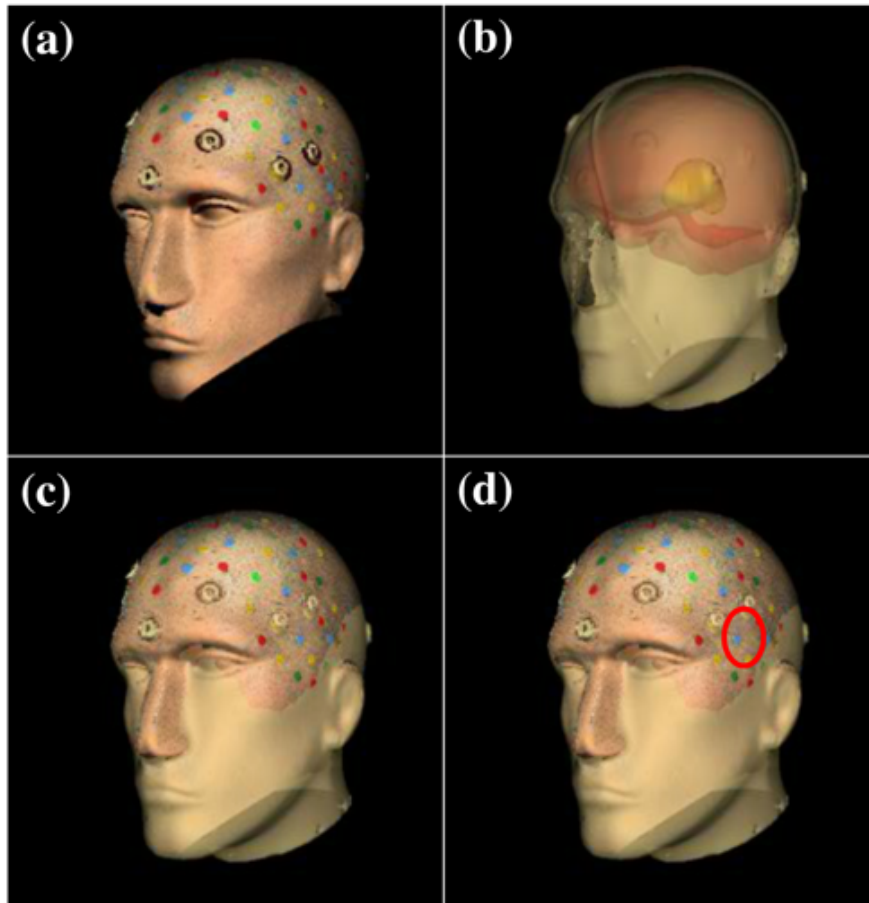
(a) Textured scan model from a 3D structured light scanner. (b) Mesh segmentation reconstruction from MR image. (c) Register textured scan model and mesh reconstruction together. (d) Overlay the virtual planning contour onto the registered head surface model.
